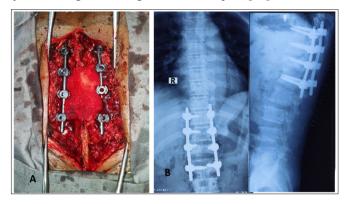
Per- operative image(A), Post operative follow-up X-ray. (B) Antero-posterior, Lateral view)
